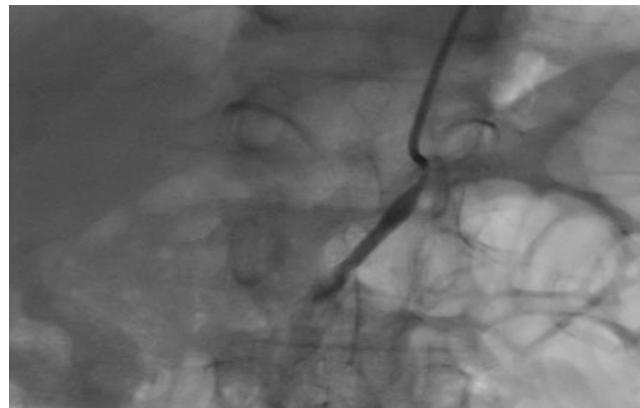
Tight stenosis of SMA, in a patient of CMI, missed for 8 years, in many hospitals. Upper and lower GI endoscopy, ultrasound of abdomen, coronary angiography were normal. Weight loss of 14 Kg in last two months.
